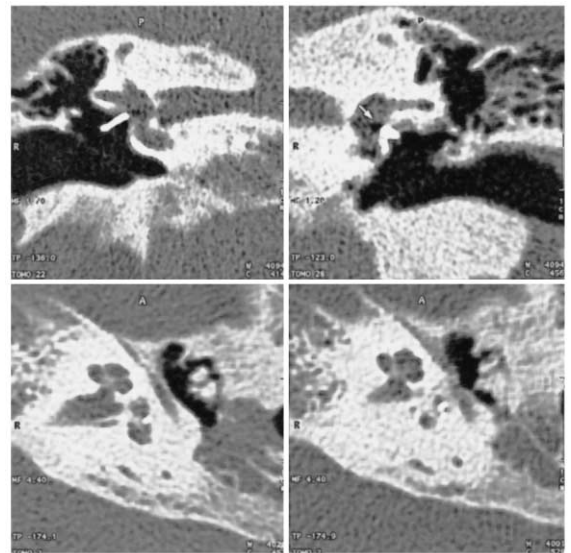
Two patients with vertigo after middle ear surgery. Upper lines: a patient after bilateral stapedotomy because of otosclerosis. Left: coronal CT shows a correct position of the prosthesis. Right: coronal CT shows a small air bubble at the end of the prosthesis (arrow) as an indirect sign of a perilymphatic fistula. CT finding was confirmed by retympanotomy. Lower lines: a patient after mastoidectomy and insertion of TORP because of cholesteatoma. Two axial CT scans show a dislocation of the prosthesis into the vestibule by recurrent inflammatory tissue and a partial ossification of labyrinth.
